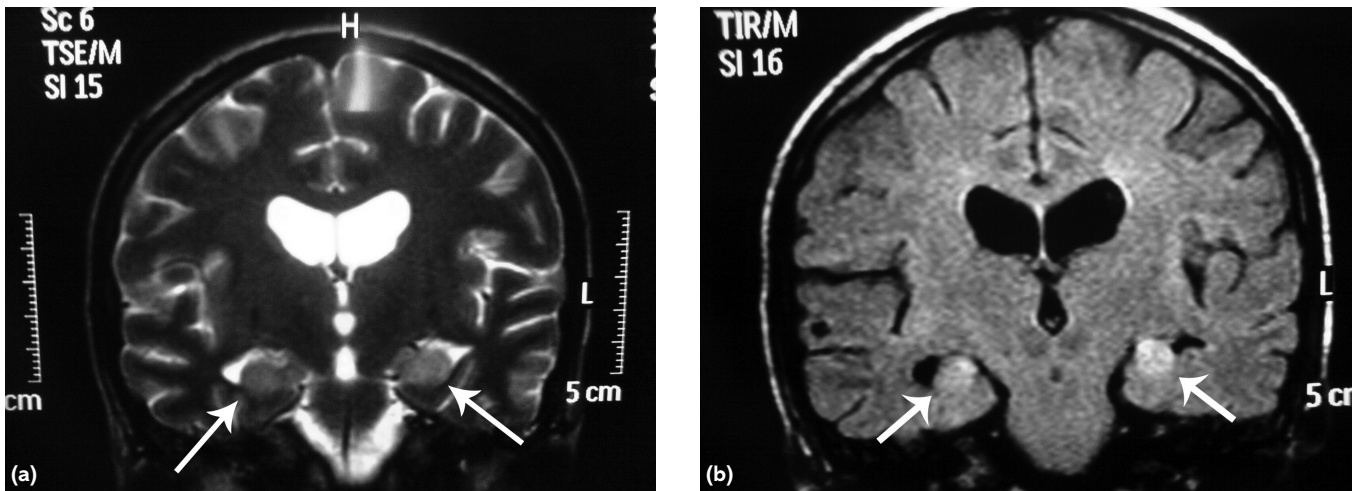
Magnetic resonance images in limbic encephalitis: (a) T2 and (b) fluid attenuated inversion recovery (FLAIR) coronal images from a case of limbic encephalitis with characteristic high signal demonstrated in the hippocampus (arrows) bilaterally in (b). For comparison, the hippocampus is also marked with arrows in (a) (images courtesy of Dr A Mohd Nor, Derriford Hospital).
